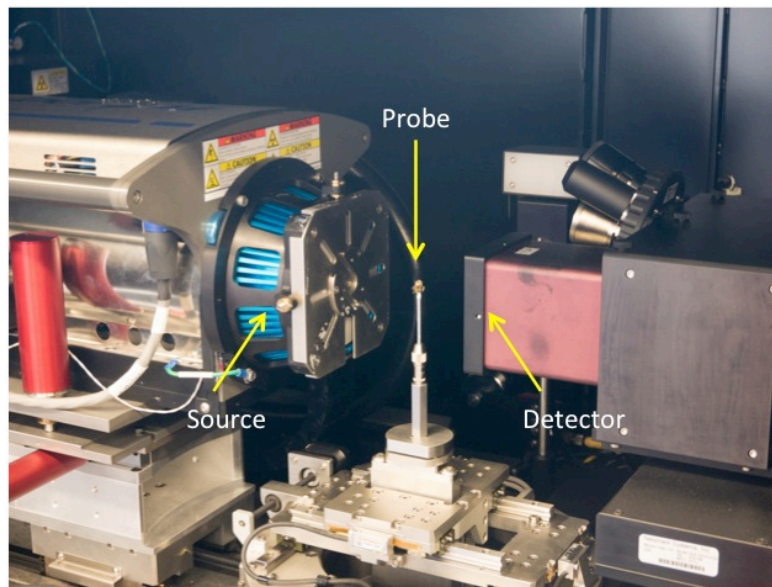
The X-Radia VersaXRM-500 setup. It consists of the X-ray source, the sample holder, the detector, and a turret of objectives. Picture courtesy of Jolanda Schwarz, E17 TUM.
